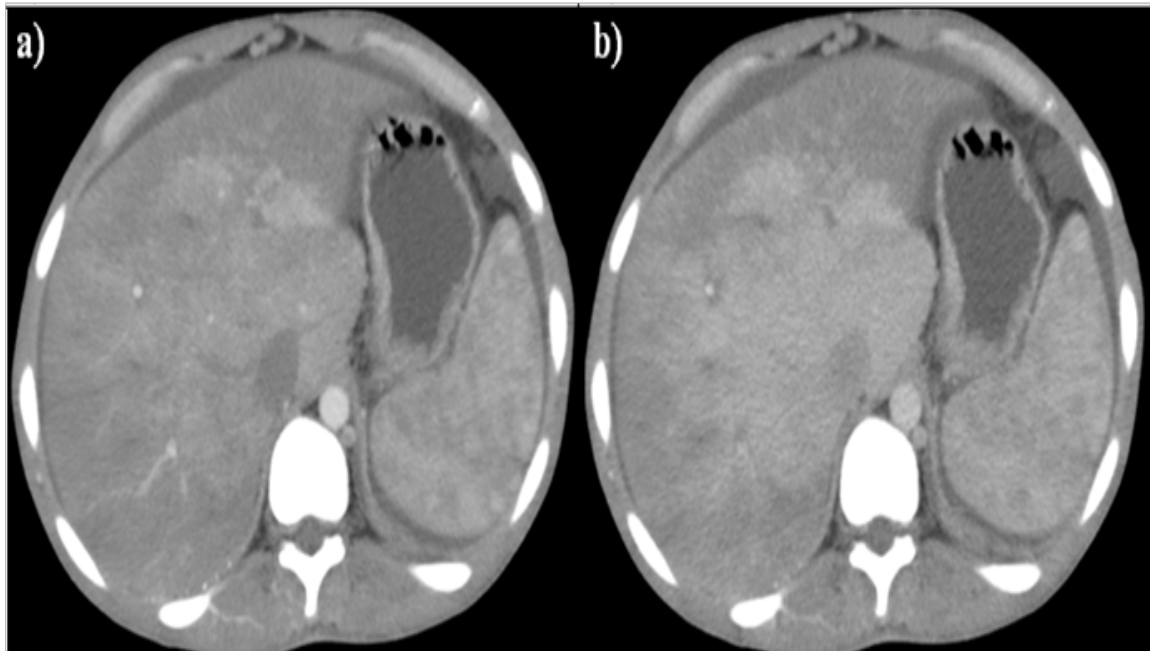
Liver transverse contrast-enhanced CT image acquired with FTC and ATCM techniques. a) is CT image scanned at FTC ( $CTD_{vol} = 20.40$  mGy,  $CNR = 13.20$  HU) and b) is CT image scanned at ATCM ( $CTD_{vol} = 12.20$  mGy,  $CNR = 15.84$  HU) of patient number 28.
